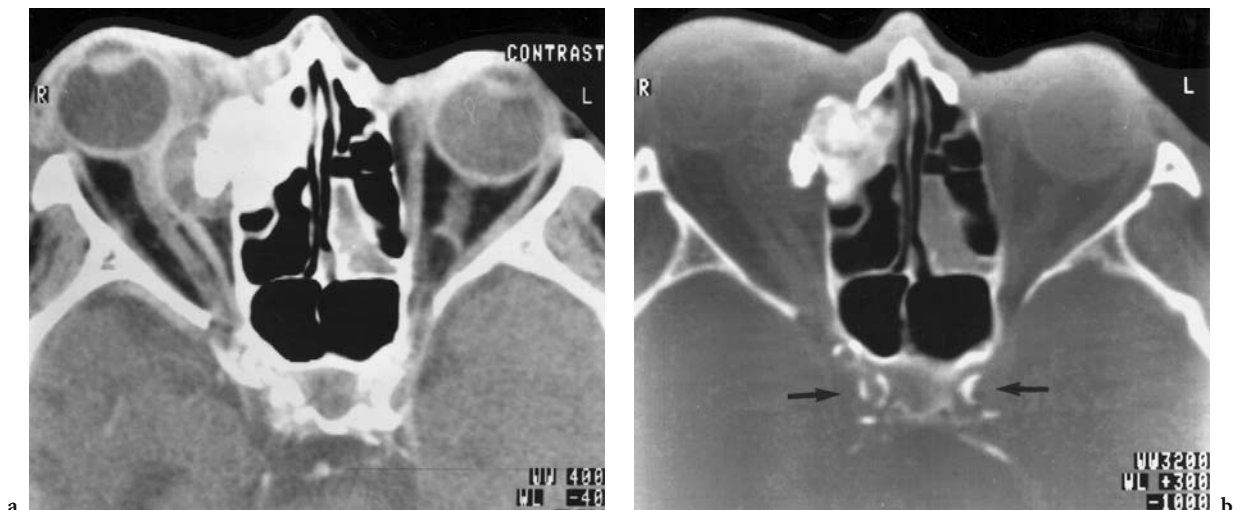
A 73-year-old woman with progressive, painful orbital swelling and rubeosis of the right eye. Diagnosis: superinfected osteoma of the lamina papyracea. Axial CT: a After i.v. contrast, visualization of a capsulated formation of mixed density originating from the surface of an ethmoid osteoma in the right extraconal space. Inflammation with pre- and postseptal extension, displacing the medial rectus muscle up to the also dislocated optic nerve, representing the cause of extra-axial proptosis. b The bone window demonstrates the mixed density of the intraorbital osteoma of the frontal ethmoid. Note bilateral calcification of the cavernous part of the ICA (arrows). (With permission of MÜLLER-FORELL and LIEB 1995b)
